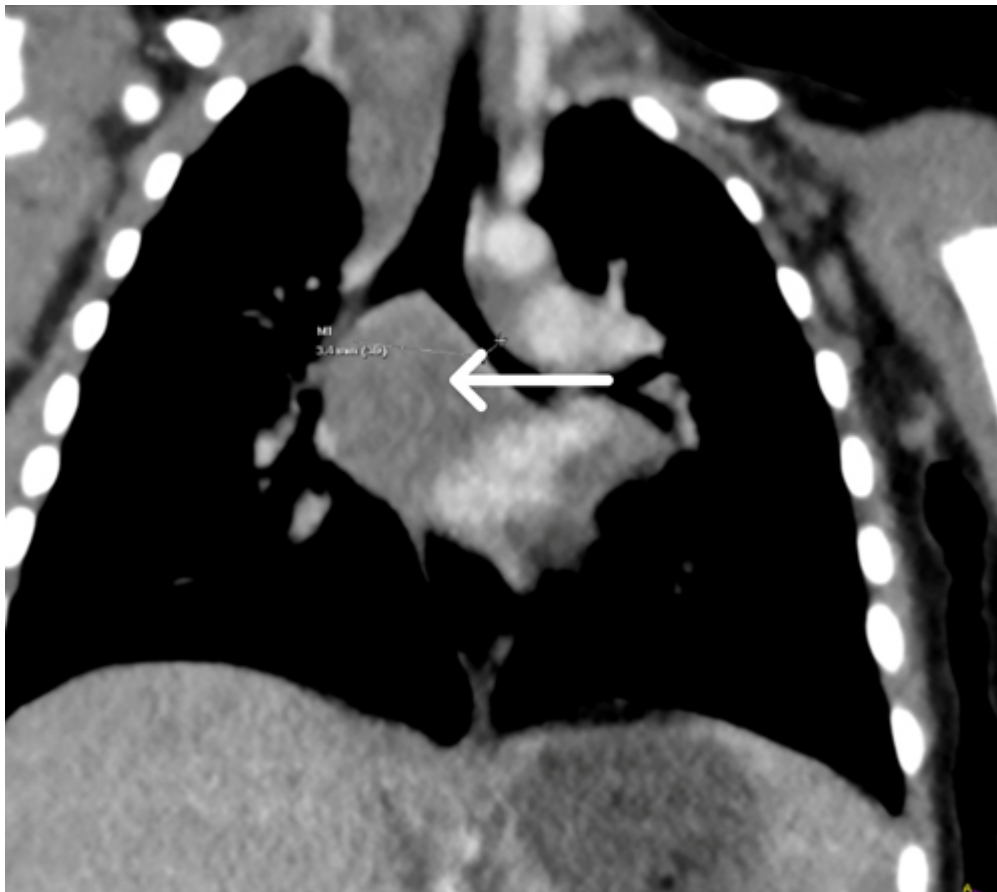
Coronal reconstruction of CT scan showing a very large subcarinal LN with necrosis and near-complete occlusion of the BI.
